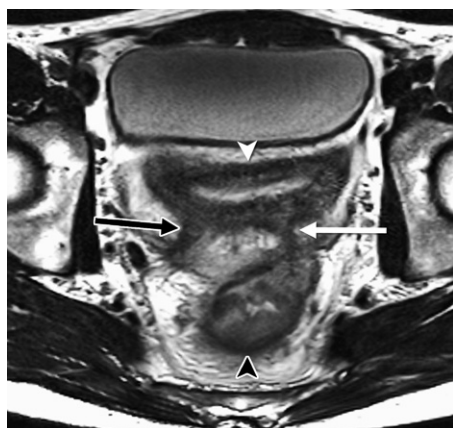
Sinus tract and simple fistula. Axial T2-weighted MR enterographic image with biphasic oral contrast material shows severe small bowel wall thickening and bowel wall edema in the ileum (white arrowhead) and rectosigmoid colon (black arrowhead), findings consistent with active inflammatory Crohn disease with an associated enterocolic fistula (white arrow) and a blind-ending sinus tract (black arrow) arising from the ileum.
